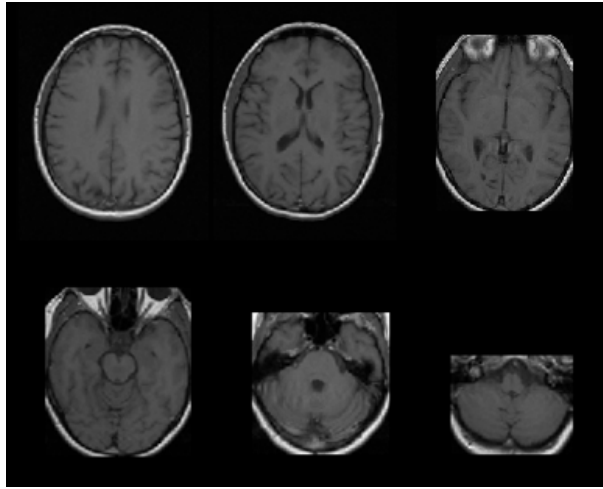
Brain MRI scans preprocessed by Inverted Cone
